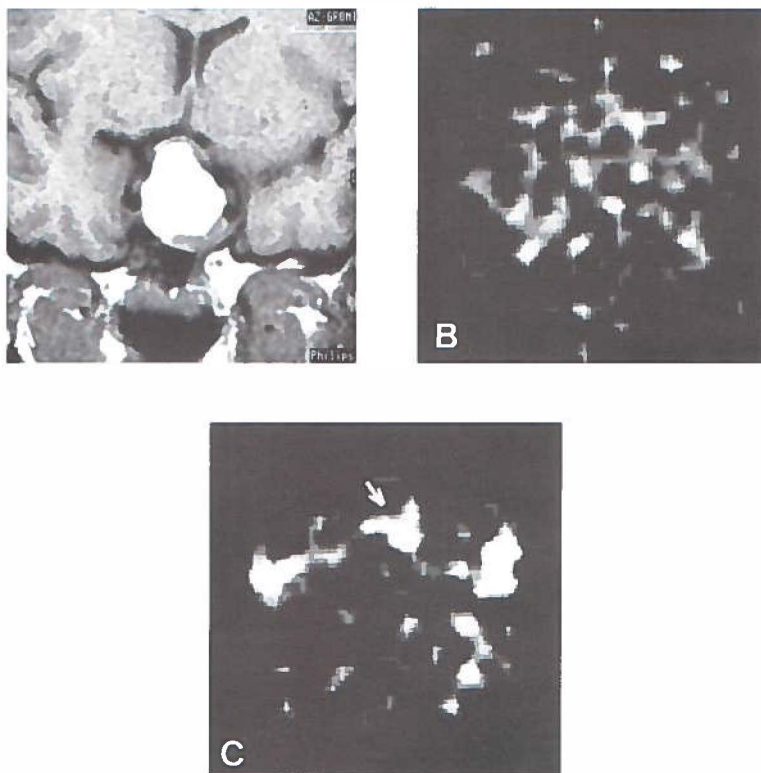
(A) MRI study (patient 4) with clear visualization of the untreated prolactinoma in a coronal slice. (B) PET study with ^{18}F FDG of the same untreated patient in a transaxial slice, no visualization of tumor was achievable. (C) Corresponding PET study using L-[^{11}C]tyrosine, position of the tumor is indicated with an arrow, the contralateral spots reflect uptake of ^{11}C -radioactivity into the parotid salivary glands.
